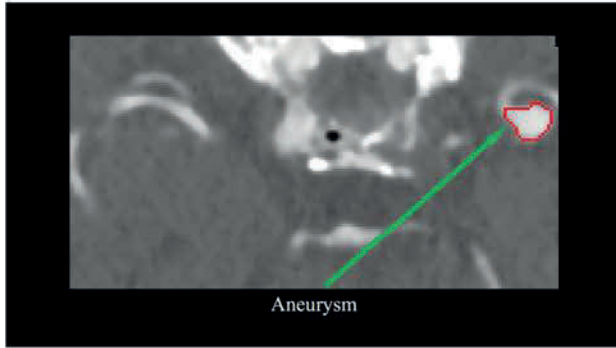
Cross-sectional image acquired by CT scan
